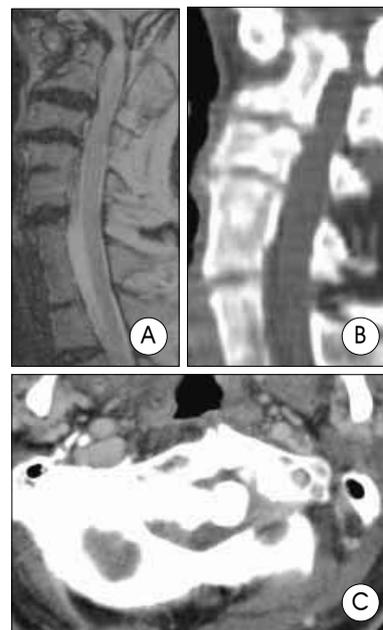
A : Sagittal T2 weighted magnetic resonance reveals a compressed cord at the foramen magnum and C2/3 interspace, and also shows C4,5 and C6,7 block vertebrae. B : Saggital computed tomography shows basilar impression and C1 assimilation. C : Axial computed tomography shows chronic rotation anomaly and severe stenosis.
